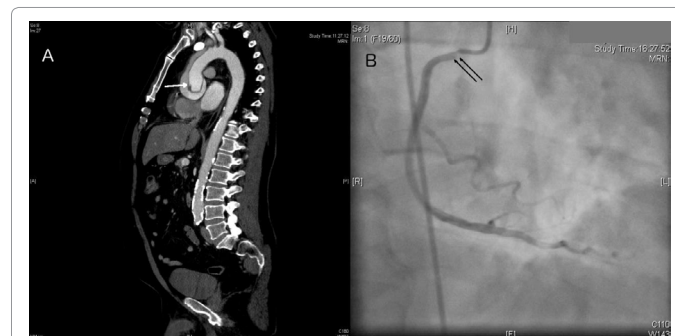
a) Computed tomography revealing the dissection of the ascending aorta involving the aortic root (arrow). b) angiogram of the dissected right coronary artery. The dissection flap obliterates partially the coronary orifice (double arrow).
